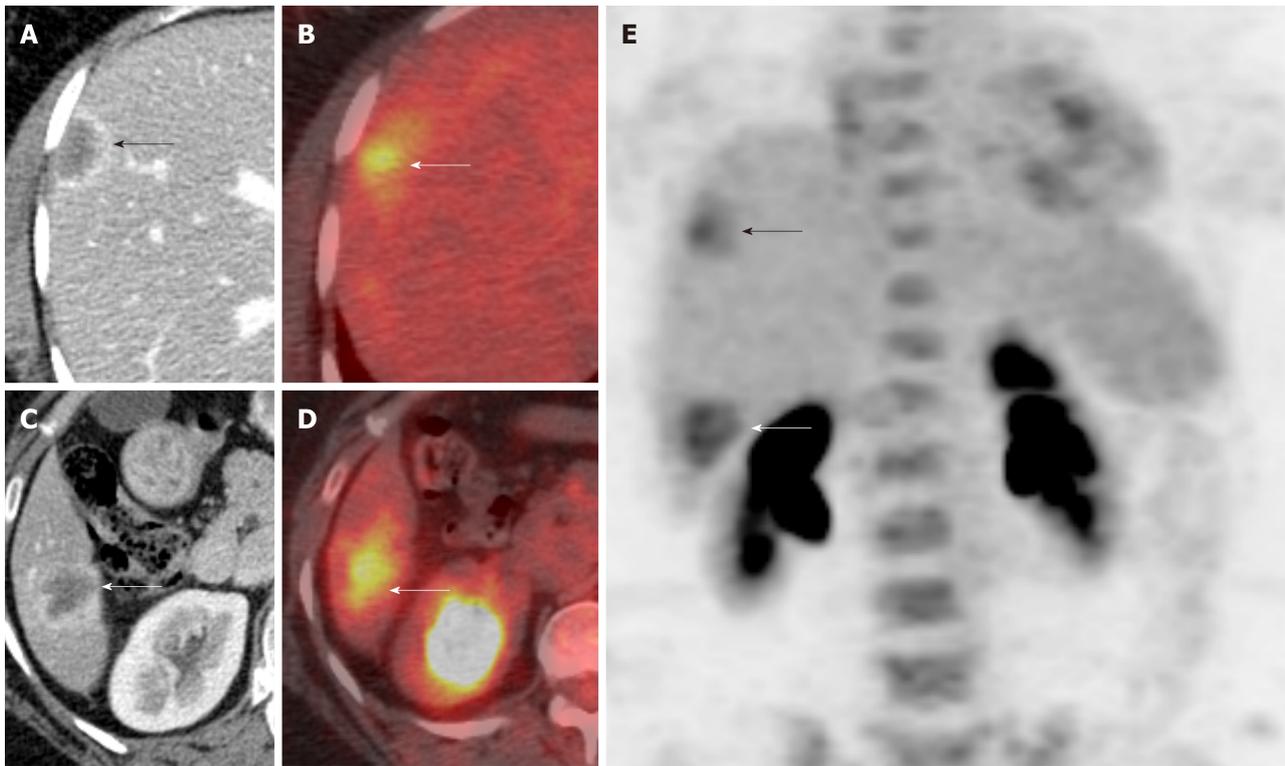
Imaging of hepatic hemangioepithelioma. A and B: Axial contrast enhanced (Computed Tomography) CT images show hepatic hemangioepithelioma nodules (arrows); C and D: Axial ^{18}F -labeled fluoro-2-deoxyglucose positron emission tomography/computed tomography; E: Coronal maximum intensity projection images shows fluoro-2-deoxyglucose avid hepatic hemangioepithelioma nodules (arrows).
